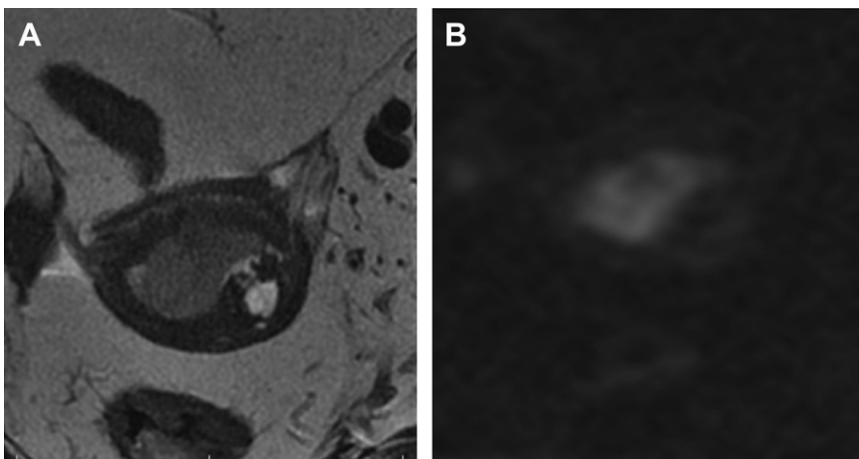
Endometrial cancer confined to the endometrium and coexisting posterior adenomyosis. (A) Coronal oblique T2-weighted image. (B) DWI was useful in assessing absence of myometrial invasion.
